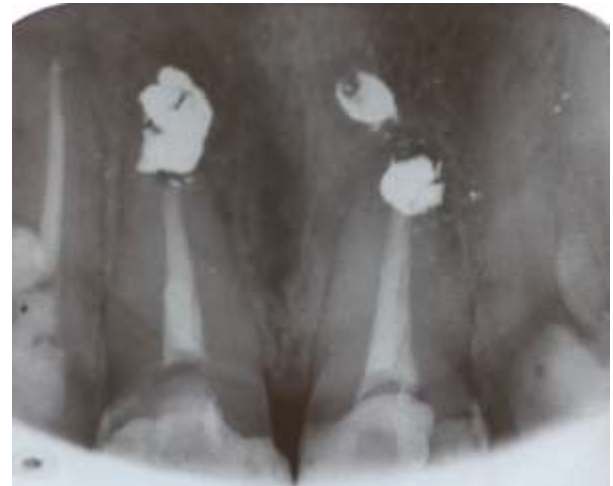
Periapical view before re-surgery
